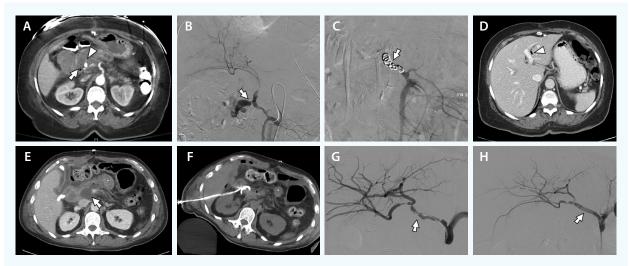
Gastroduodenal hemorrhage after the Whipple procedure. A 76-year-old man with pancreatic adenocarcinoma presented 1 month after a Whipple procedure with hematemesis. Upper endoscopy showed a patent anastomosis with no active bleeding. Axial CT image with contrast showed a fluid and gas collection in the pancreatic bed (arrow) and a small focus of contrast extravasation (arrowhead) (A). The patient had a bout of hematemesis and loss of consciousness with decline in systolic blood pressure to 70 mm Hg and a corresponding decline in hemoglobin from 10 to 8 g/dL. The patient was urgently intubated and transferred to interventional radiology with vasopressor support initiated. Visceral arteriography demonstrated a replaced common hepatic artery to the superior mesenteric artery, with rapid active extravasation from the gastroduodenal artery stump (arrow) (B). Given the patient's hemodynamic instability, coil embolization (arrow) of the proper to common hepatic artery was performed, covering the area of extravasation (C). Axial CT images from follow-up 6 months later showed no atrophy or evidence of prior hepatic necrosis; despite loss of arterial supply, portal venous flow supported liver function. Pneumobilia (arrowhead) was noted, as a result of the bilioenteric anastomosis portion of the Whipple procedure (D). In a companion case, a 56-year-old man with pancreatic adenocarcinoma presenting 2 weeks after Whipple procedure with fevers and leukocytosis was found to have a collection in the operative bed on contrast-enhanced axial CT (E). The patient underwent transhepatic drainage of the collection, yielding pus (F). Within 1 day, output from the drain became bloody and the patient became hypotensive. Vasopressors were initiated and the patient transferred to interventional radiology. Celiac arteriography demonstrated irregularity and spasm of the common and proper hepatic artery (arrow), although there was no active extravasation (G). A covered stent was placed across the gastroduodenal stump (arrow), with preservation of distal hepatic arterial blood flow (H). After the procedure, the patient improved with reduced pressor requirement; however, the patient ultimately expired the following day.
